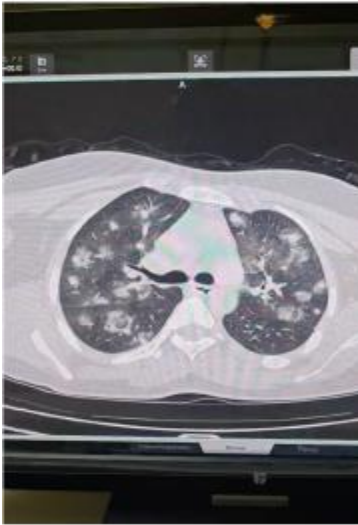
Axial HRCT Thorax: bilateral consolidation with peribronchovascular thickening and ground-glass opacities at the level of the carina.
